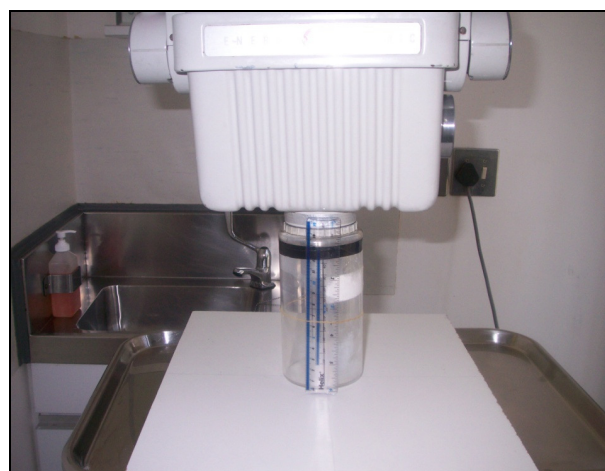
The standardized method used to radiograph each restored premolar tooth
